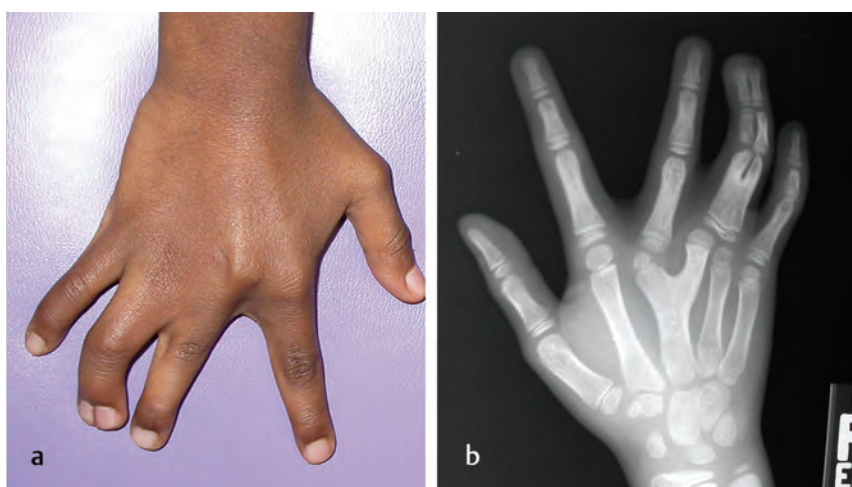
(a) Clinical example of central polydactyly. (b) Anteroposterior radiograph of the same hand.
